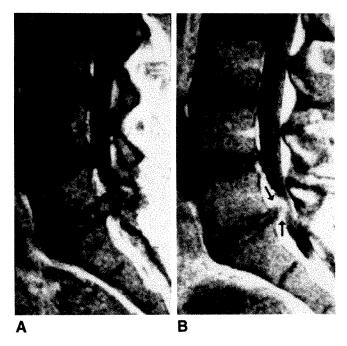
Enhancement of epidural scar. Sagittal T1-weighted images. A, Precontrast image shows large soft-tissue signal mass contiguous with L5-S1 disk space.
